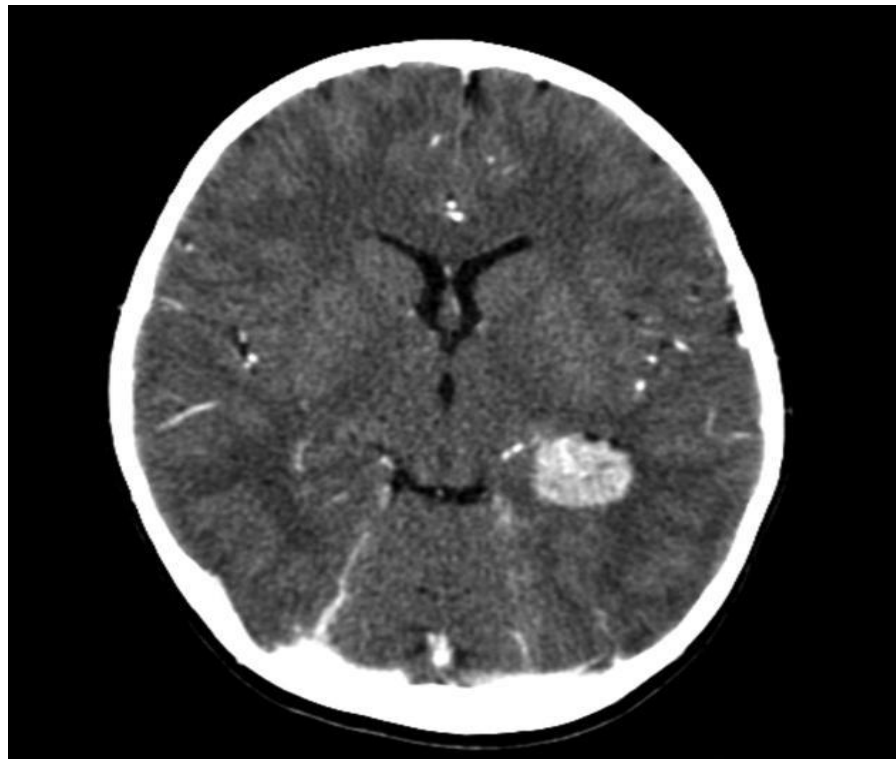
CT scan shows vascular disease.
